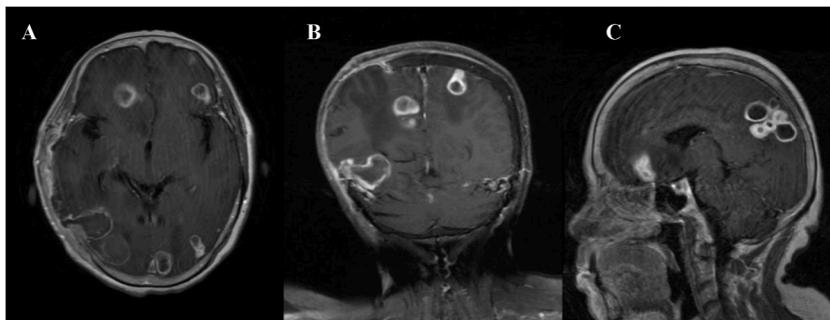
Follow-up contrast-enhanced MRI before dischargement, A (T1W transverse axis), B (T1W coronal) and C (T1W sagittal) showed the meninges surrounded by the surgical areas were thickened and enhanced, and the lesions further shrinking in size compared with those in the previous film, no newly additional lesions were found.
